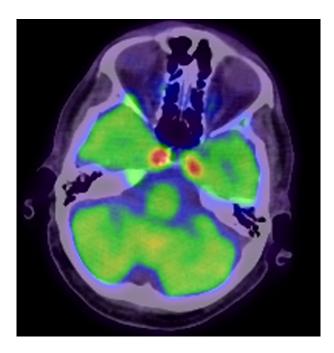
Axial ¹⁸F-FDG PET/CT of the brain showing bilateral intense avidity of the cavernous sinus.
